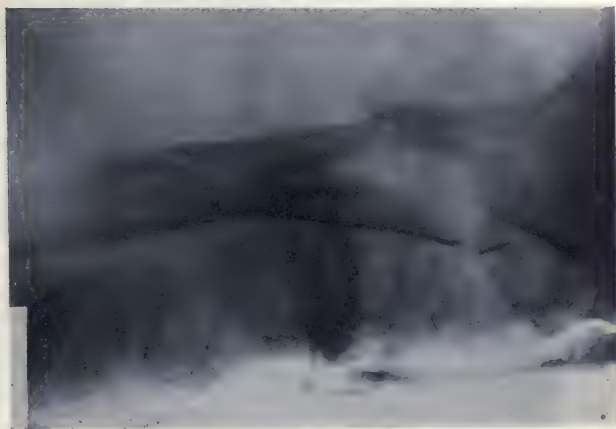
x-Ray of same (Fig. 203) after adjustment in cast (Case II).
